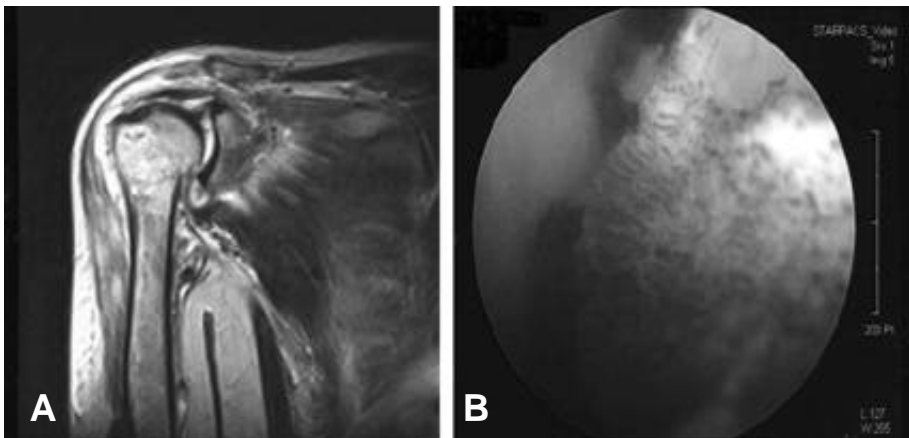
A 56 years old man had local injection at private clinic. Coronal and axial MR demonstrates findings similar to stage I. There is soft tissue swelling beyond the glenohumeral joint involving the deltoid. Capsular fibrosis is not evident in the MR images(A). Severe inflammation and fibrinous deposition in the anterior capsule is visualized(B).
